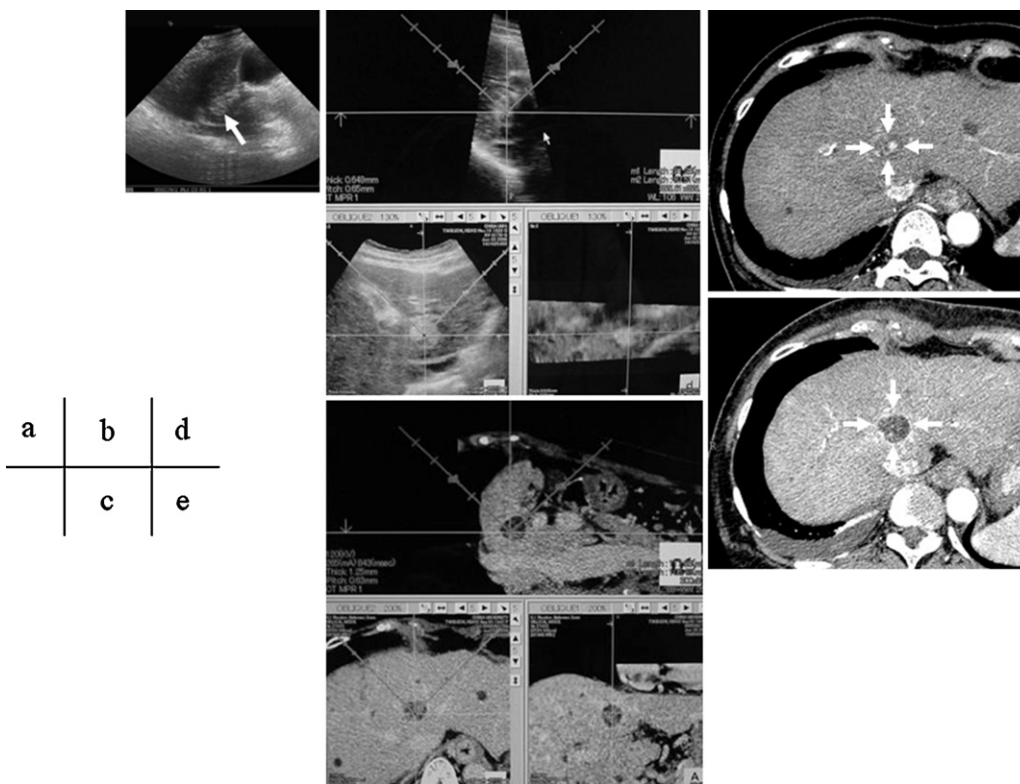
A 63-year-old female patient with an HCC. (a) The tumor (arrow) was not depicted clearly on the monitor. (b) 3D ultrasonogram. (c) 3D CT images obtained as part of the US-CT 3D dual imaging were useful for confirming the safety in the sonication zone (dotted line). (d) CT scan during the arterial phase before HIFU ablation (arrow). (e) The area of ablation is visible as a very low-density area after HIFU treatment on the CT scan obtained during the arterial phase (arrow).
